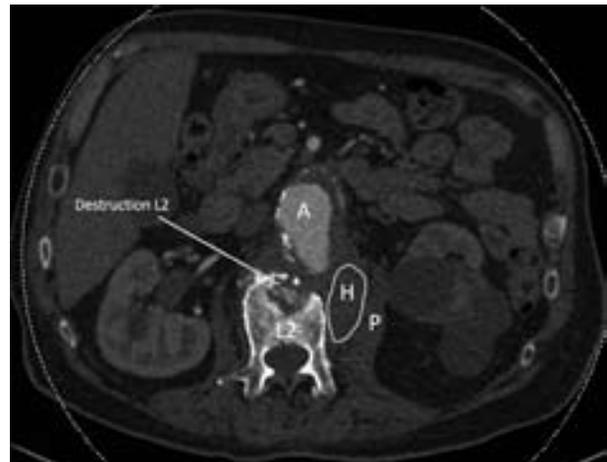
Axial CT view: Hematoma (H) surrounding the aorta (A) and left psoas muscle (P), indicating a contained rupture, and destruction of the second lumbar vertebra (L2).
